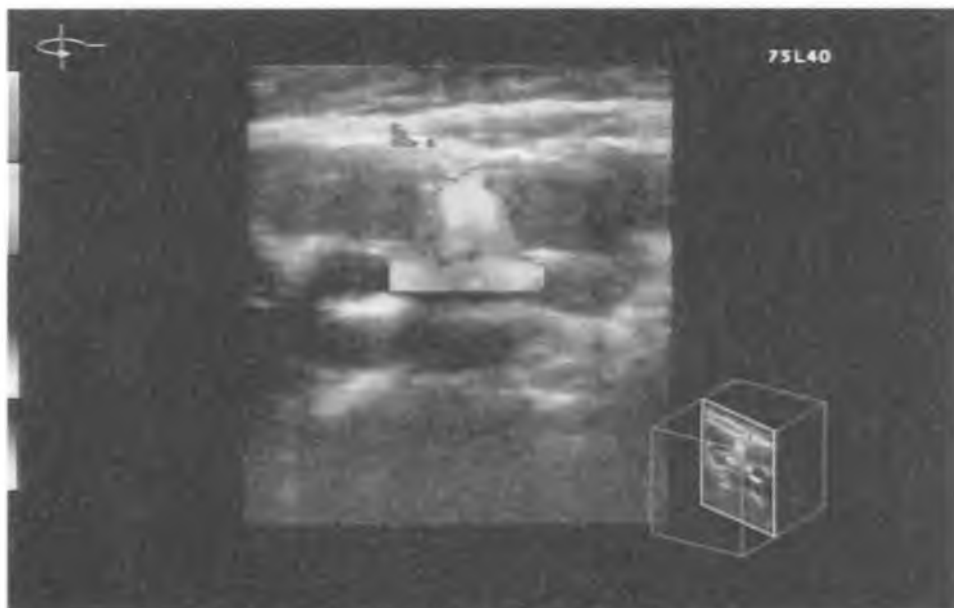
Ultrasonographic image of a lymph node. Power Doppler mode, 3D presentation. Visualised the hilus vessel
